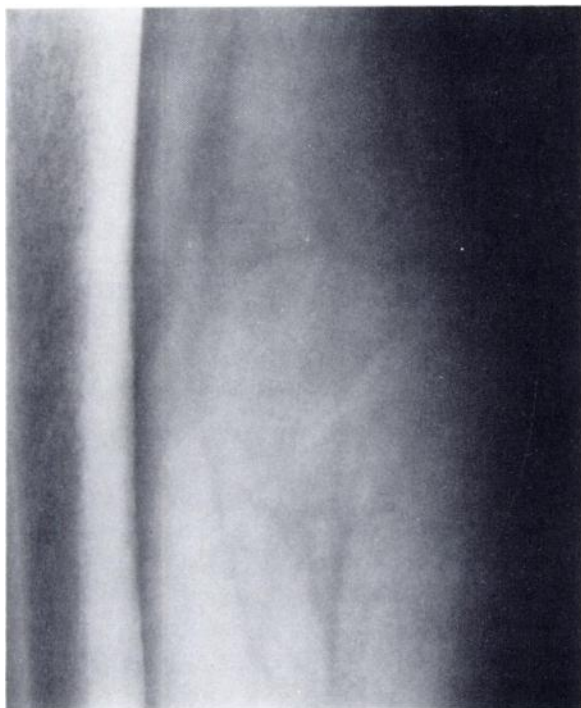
Lateral radiograph of posterior right thigh showing spherical outline of lesion in soft tissues.
